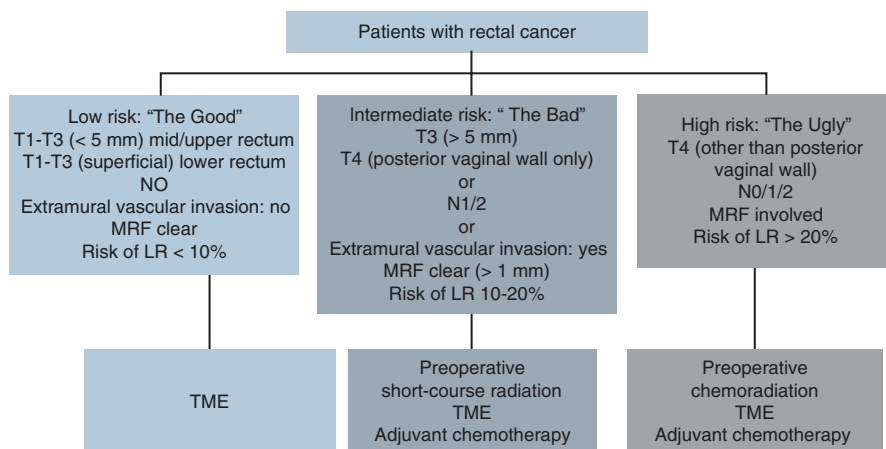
European model of stratification for patients with rectal cancer based on magnetic resonance imaging. Abbreviations: MRF, mesorectal fascia; LR, local recurrence; TME, total mesorectal excision. (Source: Ferrari and Fichera [54]. Published under the terms of the Creative Commons CC License.)
